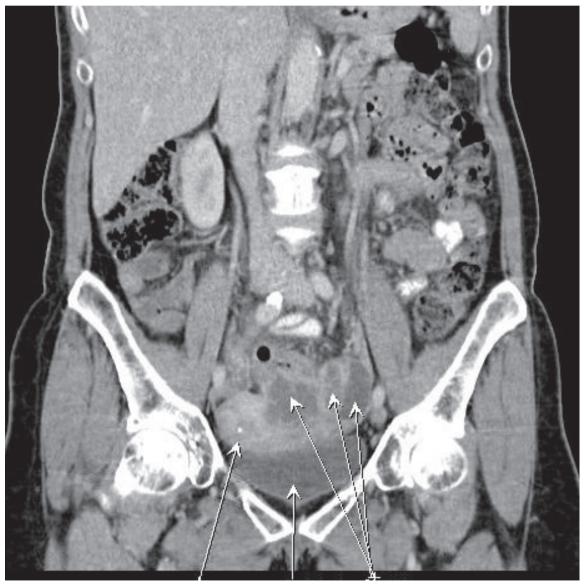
CT scan revealed solid cystic, septated, and expansive lesion in the left adnexal region, with irregular margins and left uterine horn infiltration.
